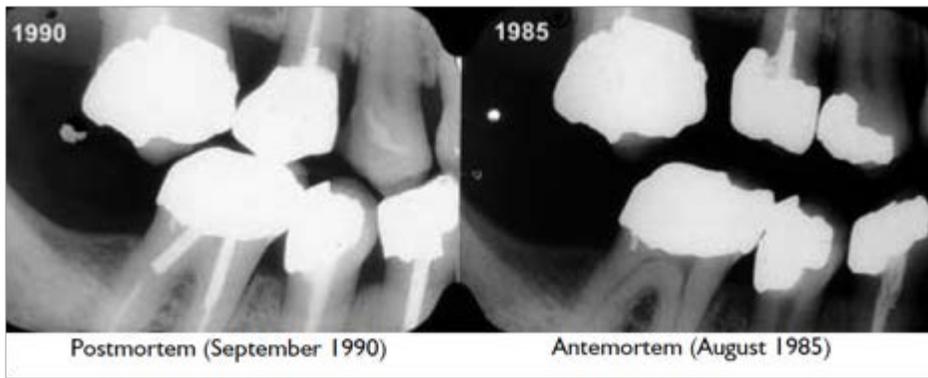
This shows a comparison of postmortem and ante mortem radiographs that were used to determine the identity of a deceased individual. After careful measurement and analysis, these two radiographs were found to be from the same person, and therefore successfully identified the victim. Note the difference between the top most right teeth of each radiograph; this can be accounted for by dental work that occurred within the time span between these two radiographs, most likely being a crown that was removed during this period. . Adapted from: Pretty, I. A., & Sweet, D. (2001). A look at forensic dentistry – part 1: the role of teeth in the determination of human identity.
